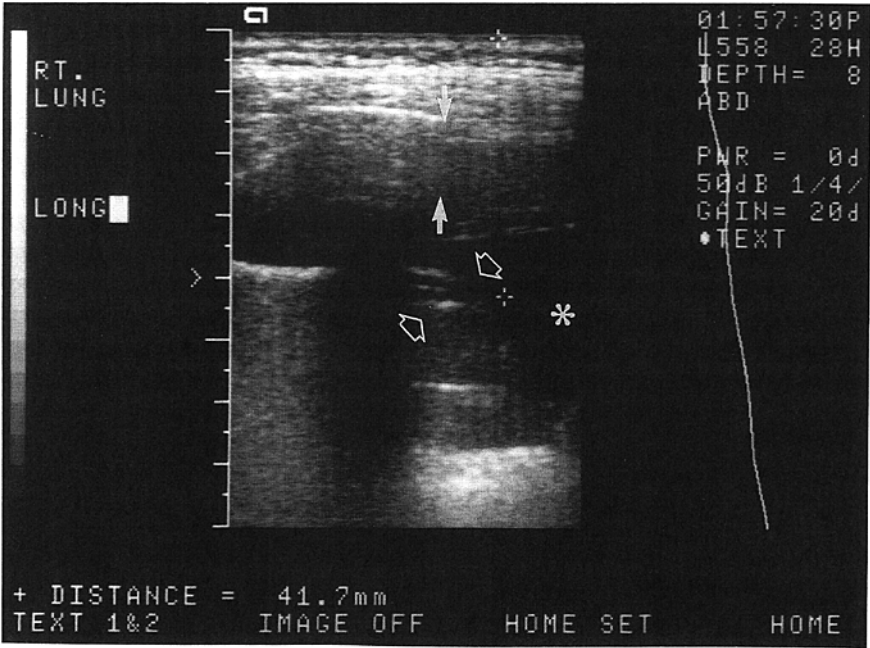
Tuberculous empyema and pneumonia. Real-time high-resolution ultrasound shows marked thickening of the visceral pleura (between arrows). Atelectatic lung (open arrows) and small amount of pleural effusion (asterisk) contribute to the opacified hemithorax.
